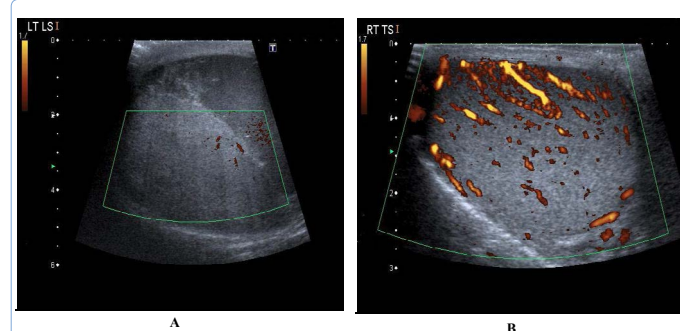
(A) Ultrasound shows left testicle with no flow on colour Doppler and tunica albuginea rupture as compared to (B), a normal right testicle with an intact capsule and healthy blood supply.
